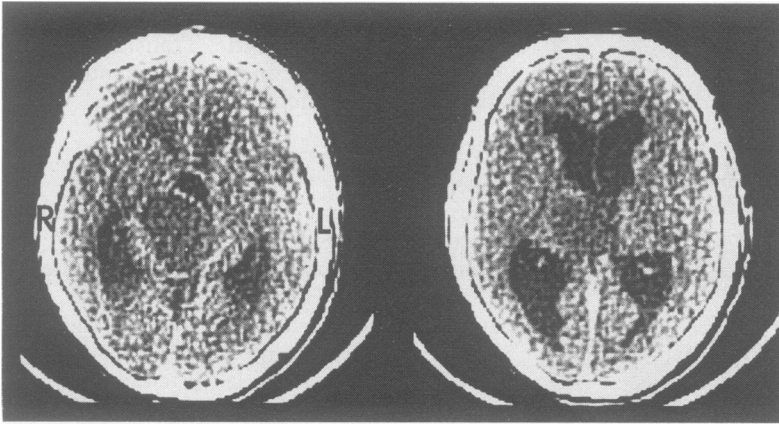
Axial enhanced CT scans of patient 1 who presented with left resting, postural and intention 3–4 Hz tremor show a cystic pilocytic grade I astrocytoma located in the right thalamus. The tremor disappeared after stereotactic aspiration of the tumour cyst.
